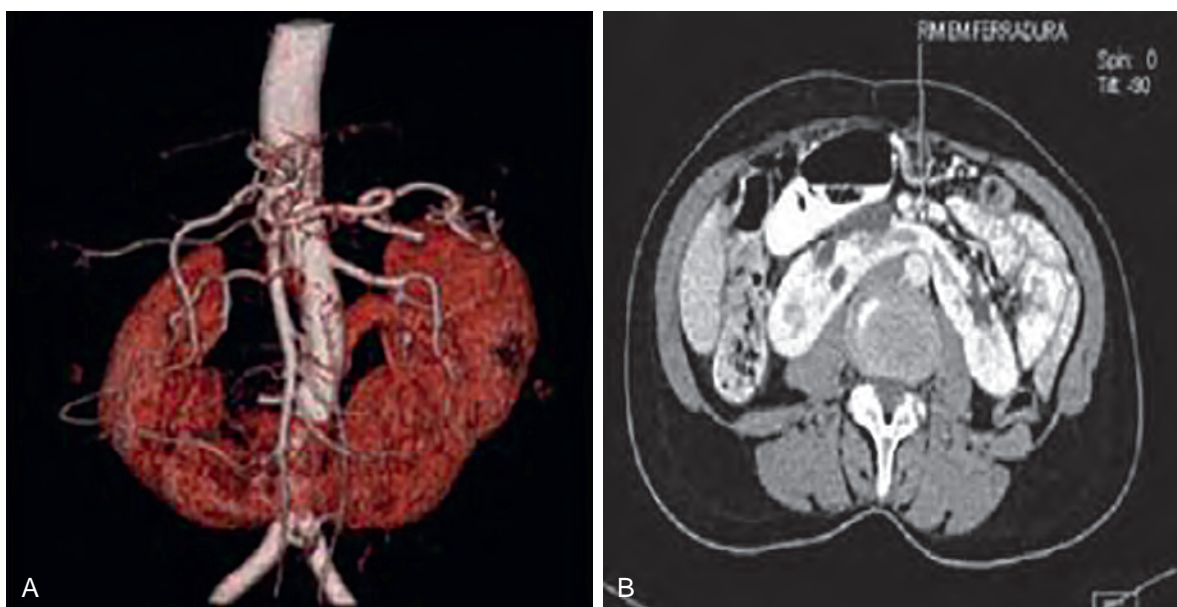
Computed tomography angiography with volume-rendered three-dimensional image (A) and axial view (B) of a horseshoe kidney showing the aberrant vasculature. (From Maranhao CP, de Miranda CM, dos Santos CJ, et al. Congenital upper urinary tract abnormalities: new images of the same diseases. Radiol Bras 2013;46:43–50.)
